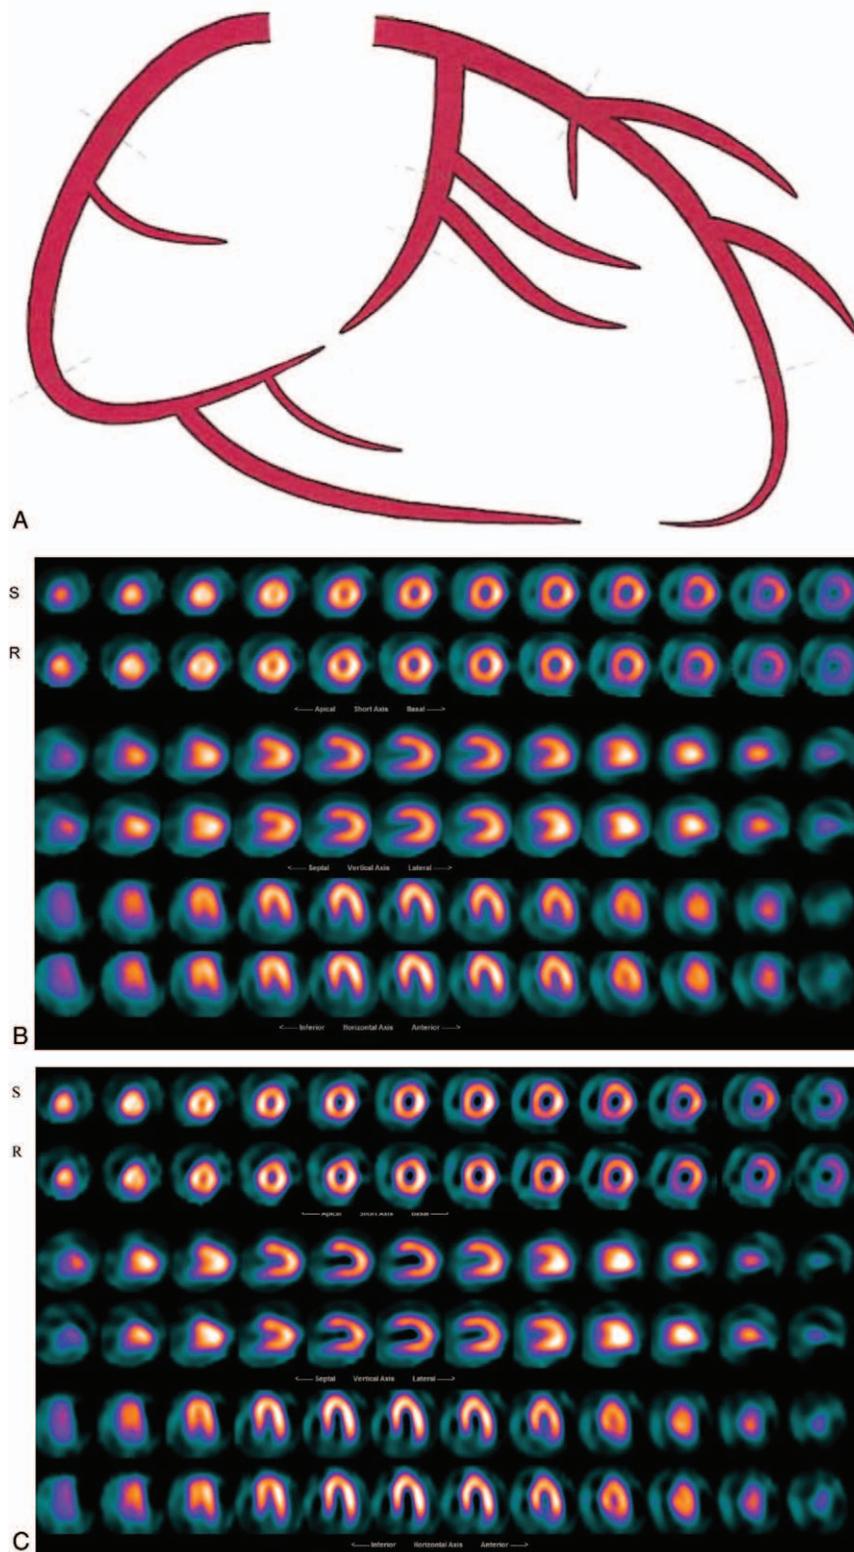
A 41 years old male patient with atypical chest pain and shortness of breath was referred to NM for assessment of possible CAD. (A): CT-angiography result reported Normal (LMCA, LAD, Diag, Circ, and RCA are normal), (B): Butterworth reconstructed SPECT results reported normal, (C): Wiener reconstructed SPECT results suggested normal with very mild diffuse uptake in basal anterolateral wall and inferior wall (likely due to diaphragmatic attenuation). Both reports were consistent with the CT-angiography. CAD = coronary artery disease, Circ = circumflex, CT = computerized tomography, Diag = diagonal, LAD = left anterior descending artery, LMCA = left main coronary artery, RCA = right coronary artery, SPECT = single photon emission computerized tomography.
